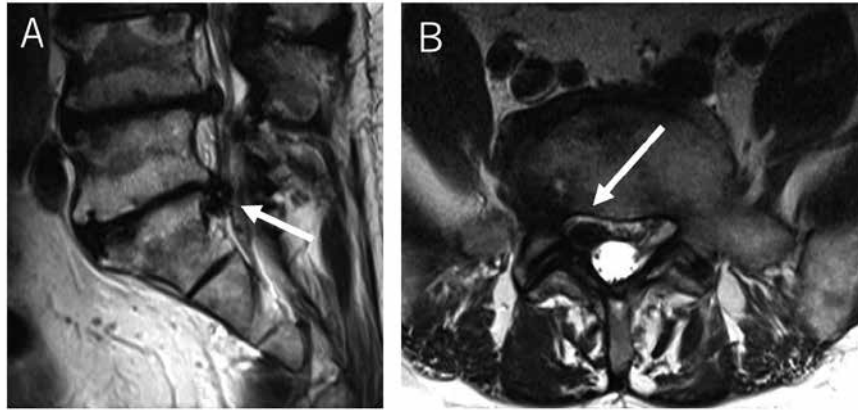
T2-weighted images obtained at L5–S1. (A) Para-sagittal image showing a herniated nucleus pulposus at L5–S1. (B) Axial image showing a mass pressing on the right S1 nerve root (arrows).
